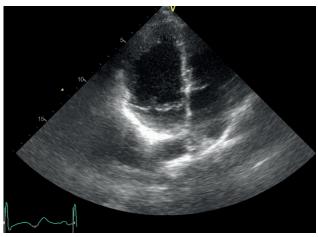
Echocardiogram in B-mode: mitral valve prolapse.
